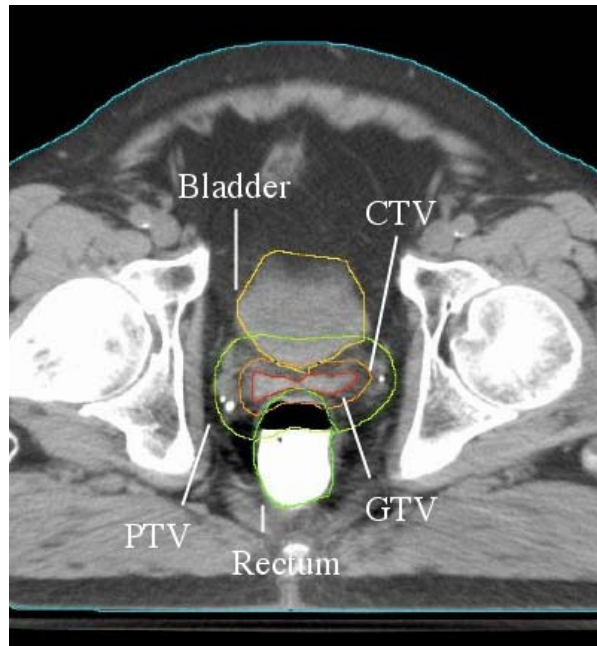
Contours of GTV, CTV, PTV and organs at risk (bladder and rectum) have been drawn on this CT slice for a prostate treatment plan.
